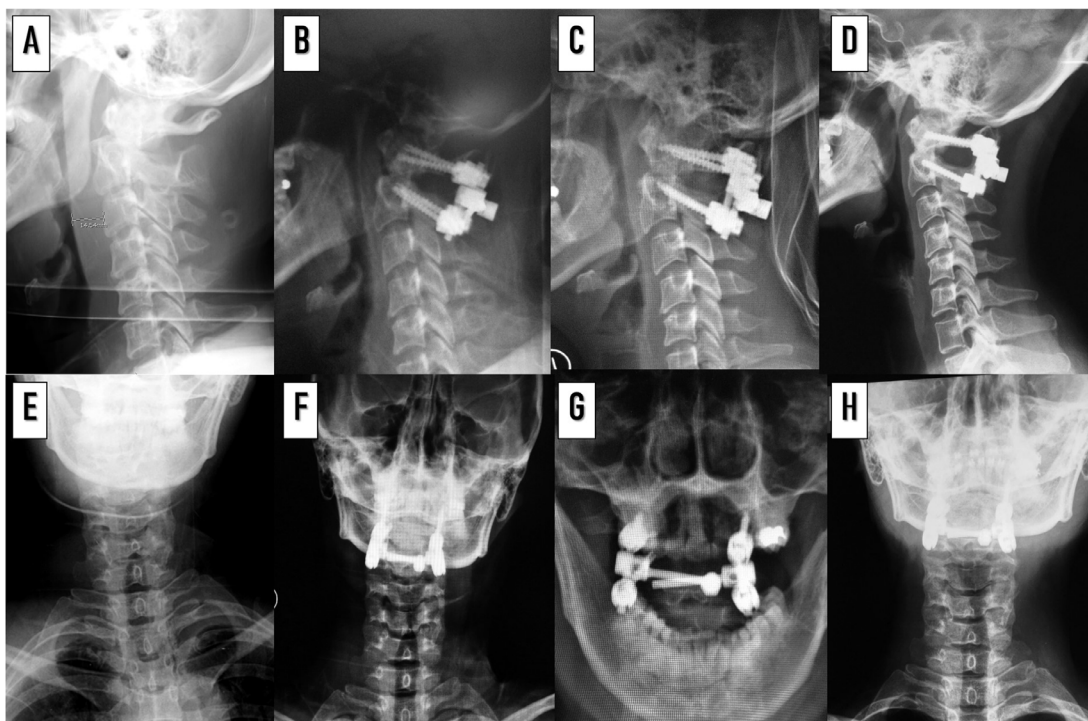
Lateral radiographic images: preoperative (A), 1 month postoperative (B), 6 months postoperative (C) and 1 year postoperative (D). AP radiographic images: preoperative (E), 1 month postoperative (F), 6 months postoperative (G) and 1 year postoperative (H).
